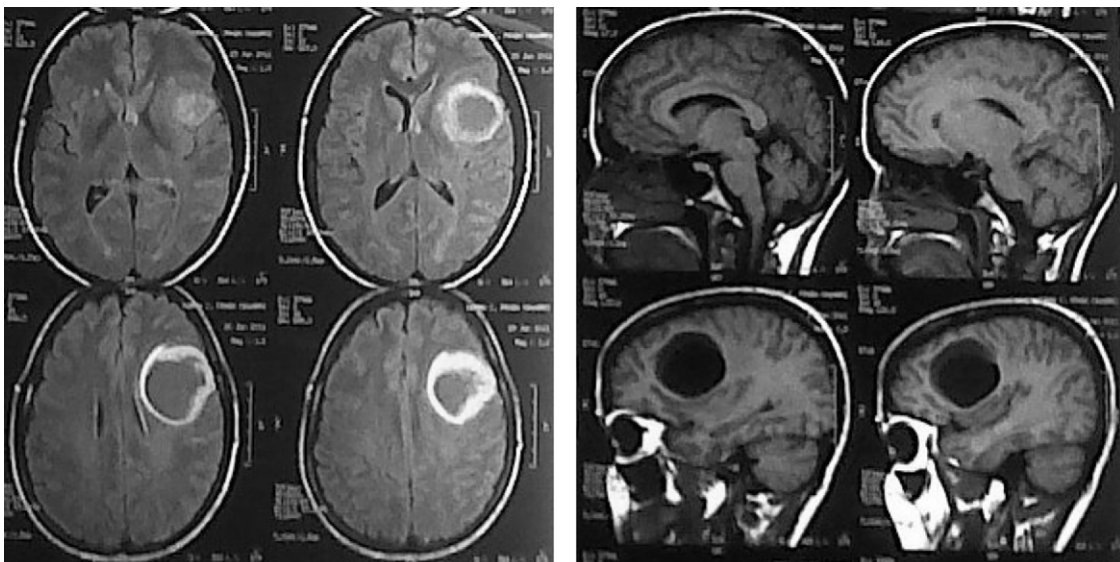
Brain MRI showing expansive lesion.
